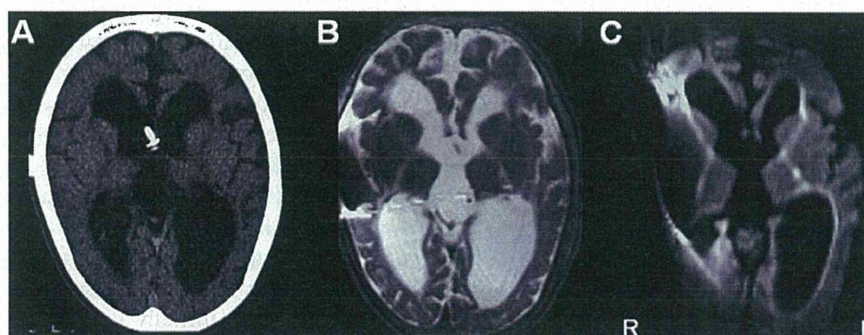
(A) Brain CT showing severely dilated ventricles and diffuse brain atrophy with dominantly affected white matter and relatively spared basal nuclei, compatible with post-meningitis hydrocephalus and brain atrophy. A ventriculoperitoneal shunt tube was placed in the left lateral ventricle. (B) T2-weighted MRI also showing diffuse brain atrophy with dominantly affected white matter. The T2 prolongation and volume loss of white matter suggested white matter injury. (C) MRI diffusion-weighted image showing a high intensity signal in white matter, suggesting white matter degeneration. Please note that the ventriculoperitoneal shunt valve causes the defects and flaring of images.
